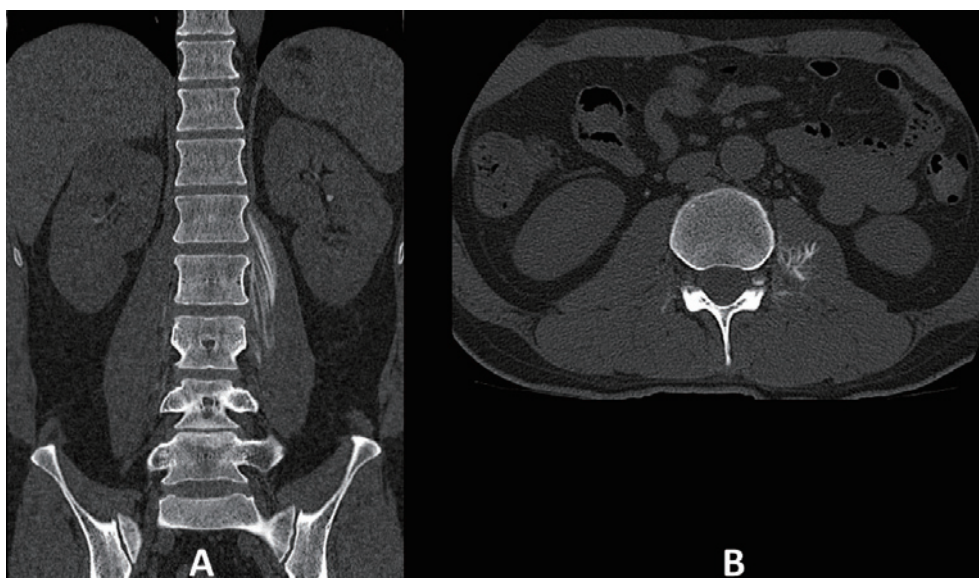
CT myelogram performed on POD 8 showing marked contrast medium accumulation at the L1-L2 level, suggesting CSF leakage around the dural sleeve of the left L1 nerve root. A, coronal image; B, axial image.
